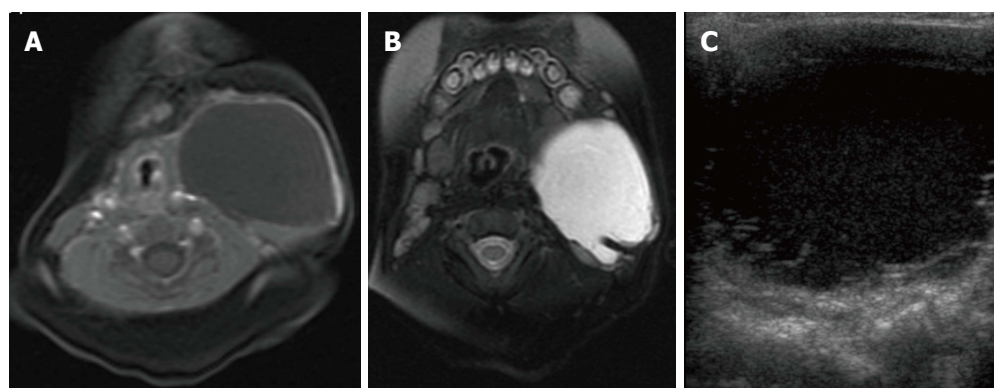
Cervicothoracic macrocystic lymphatic malformation. T1- (A) and T2-weighted (B) fat suppressed magnetic resonance images (MRI) demonstrate a macrocyst within the left neck that is predominantly hypointense on T1-weighted image and hyperintense on T2-weighted image. Trace blood products layering within the posterior aspect of the cyst are hyperintense on the T1 weighted image and hypointense on the T2 weighted image. Transverse ultrasound (C) demonstrates a predominantly anechoic macrocyst with layering low-level echoes, corresponding to blood products seen on MRI.
